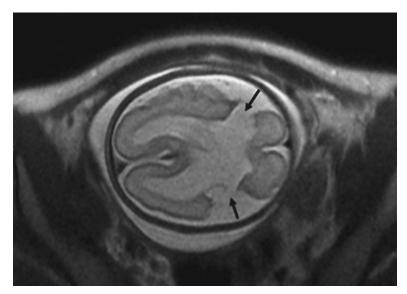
Fetal MRI shows in utero bilateral schizencephalic clefts (arrows). (Used with permission from Dr. Sarah Milla.)
